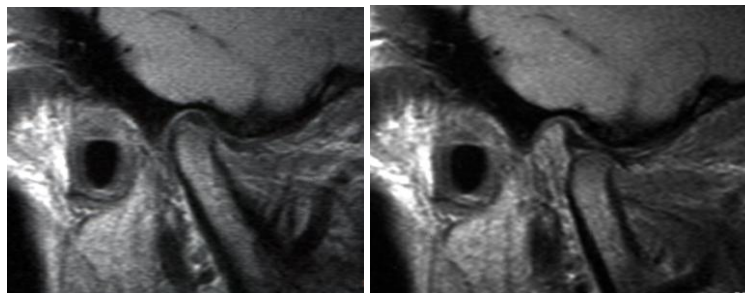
a, b: MR images of the same patient after bite correction and insertion of a bite plane; physiologic position of the condyles and disco-condylar relation
